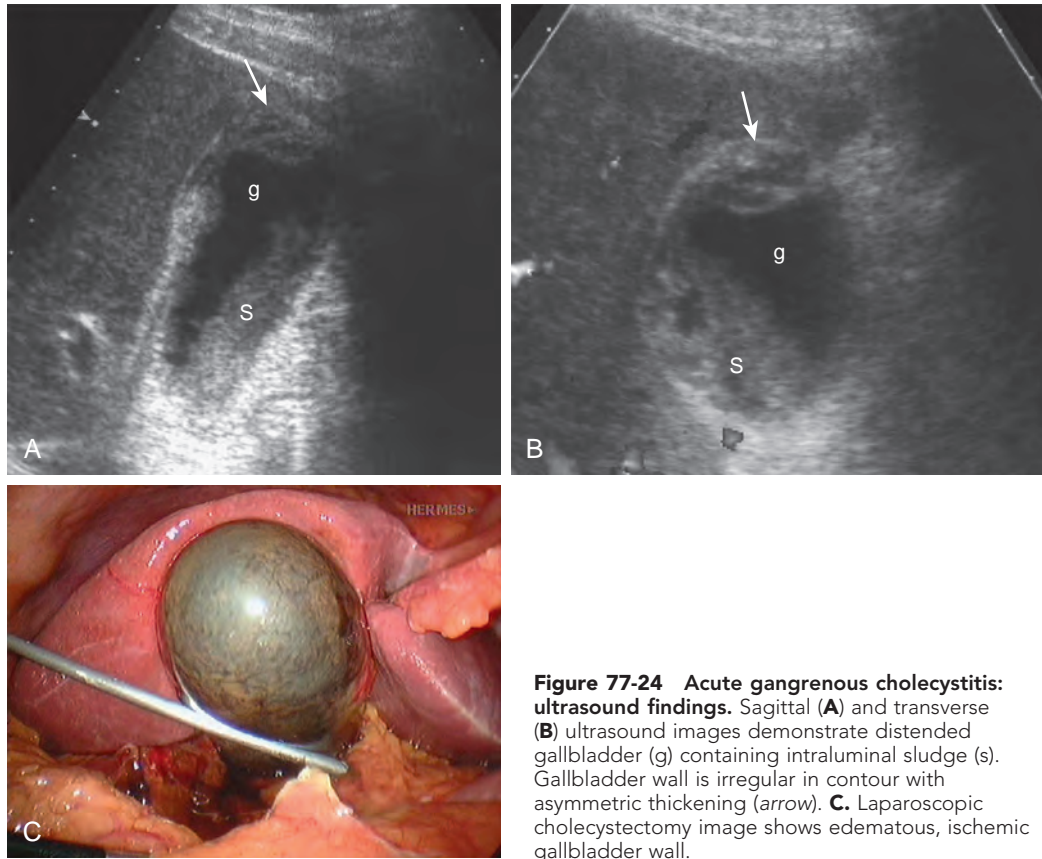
Acute gangrenous cholecystitis: ultrasound findings. Sagittal (A) and transverse (B) ultrasound images demonstrate distended gallbladder (g) containing intraluminal sludge (s). Gallbladder wall is irregular in contour with asymmetric thickening (arrow). C. Laparoscopic cholecystectomy image shows edematous, ischemic gallbladder wall.
